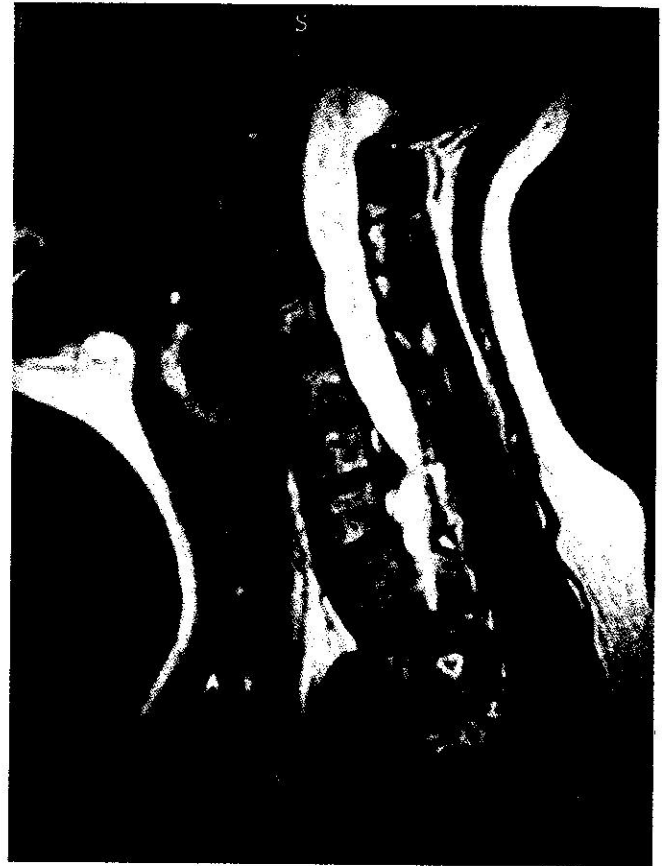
Preoperative sagittal magnetic resonance image (MRI) showing C6-7 disc degeneration and a large herniation.
